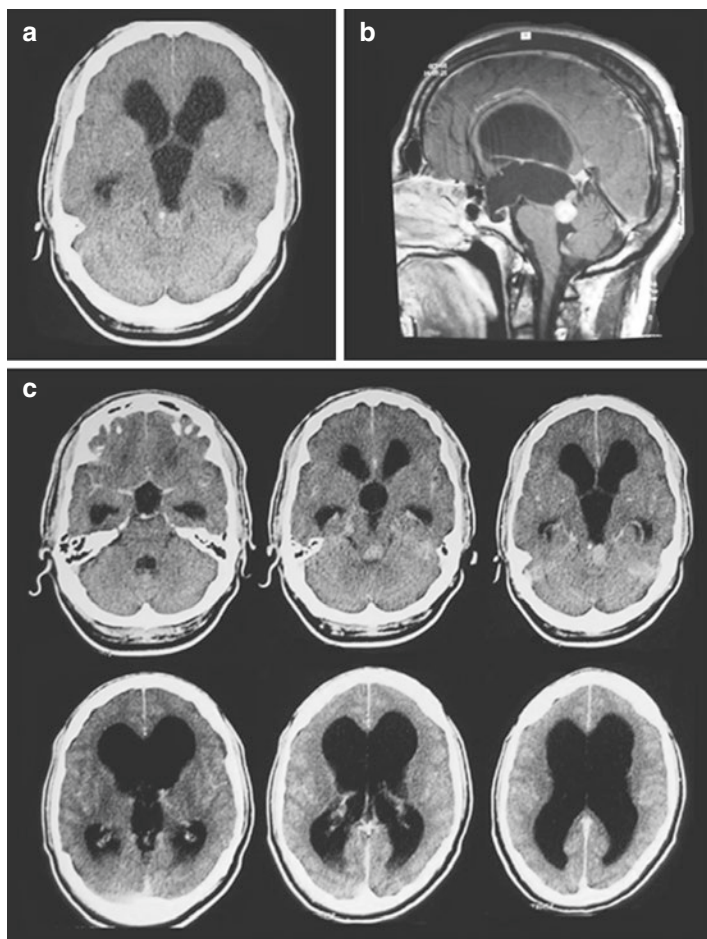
Aqueduct obstruction from pineocytoma. (a) Non-contrast axial CT; (b) sagittal post contrast MRI showing the enhancing nodule of tumor causing the obstruction; (c) post contrast CT scan showing the enhancing nodule as seen on CT. Note that the third ventricle is larger than the fourth, a reversal of the normal situation which is the hallmark of aqueduct stenosis (compare Fig. 4.10b) no matter the cause
